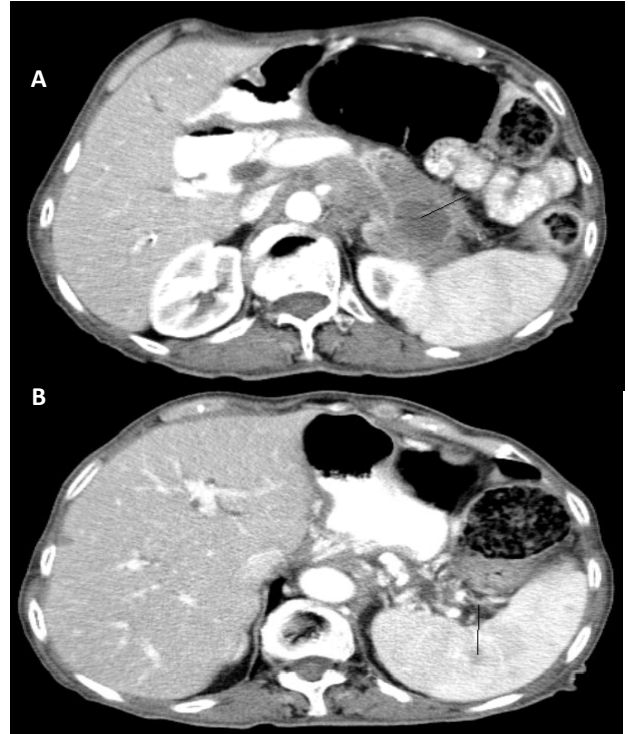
Axial CT scan after the Adriamycin, Bleomycin, Vinblastine and Dacarbazine (ABVD) chemotherapy: A) Showing the progressive mass located on the tail of the pancreas. Left para-aortic lymph node was completely disappeared. B) Showing a splenic nodule which was regressed to 7 mm after ABVD chemotherapy.
